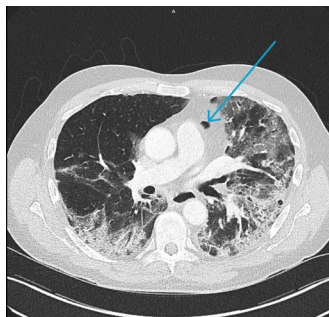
Axial CT slice of CT pulmonary angiogram from patient 1 with arrow demonstrating pneumomediastinum air locule.
